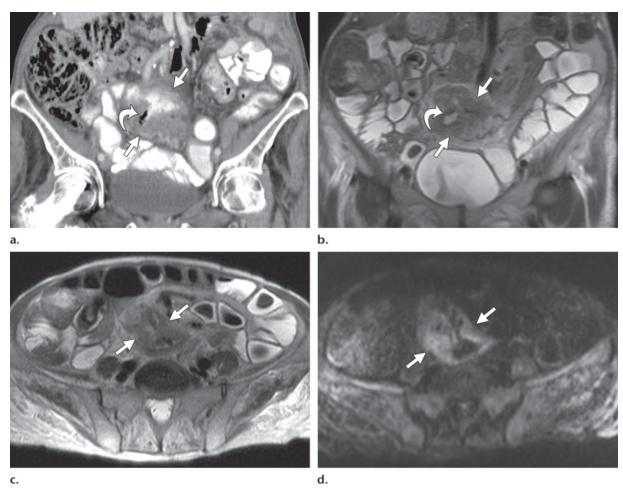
Intestinal EATL type I in a 71-year-old woman with 25-lb (11-kg) weight loss and fever. (a, b) Coronal CT image with intravenous and oral contrast material (a) and coronal T2-weighted MR image (b) show circumferential wall thickening of the mid ileum (straight arrows), with a focal area of ulceration and perforation (curved arrow). (c, d) Axial T2-weighted (c) and diffusion-weighted (d) MR images show wall thickening of the mid ileum with restricted diffusion (arrows).
